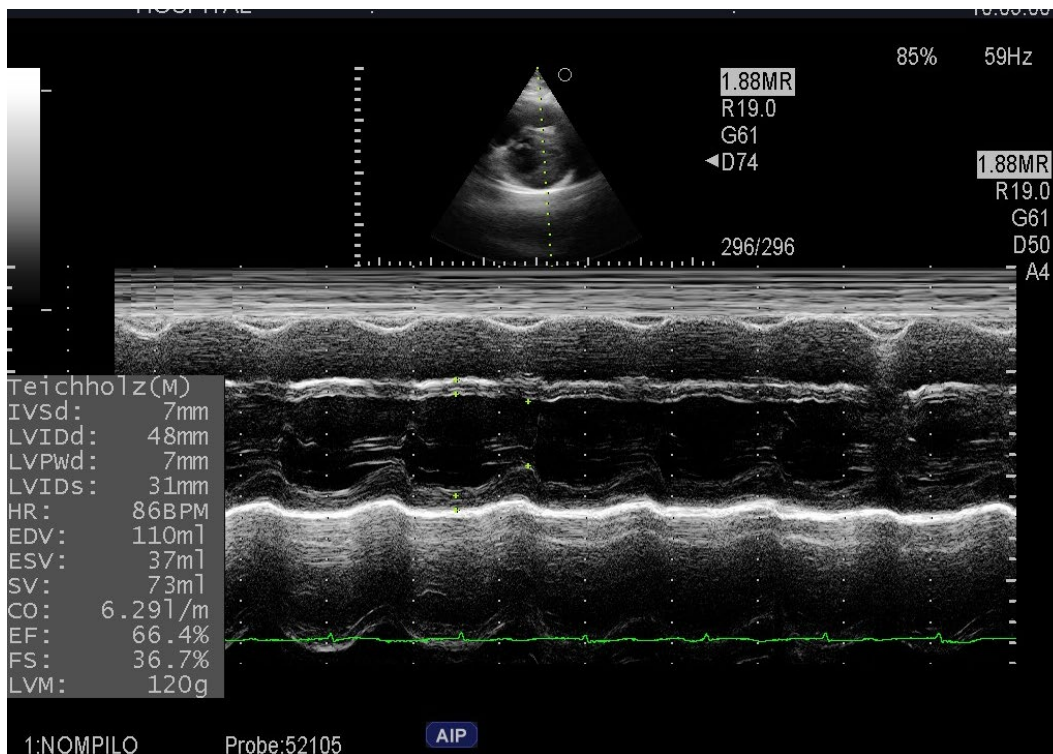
M-mode in parasternal long axis view for LV dimension and ejection fraction.
